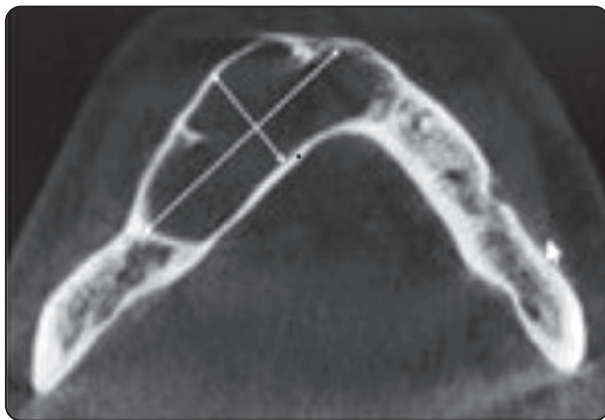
Keratocyst. Axial view of cone-beam computed tomography image showing a width-to-length ratio of $1.5/3.92 = 0.38$.
